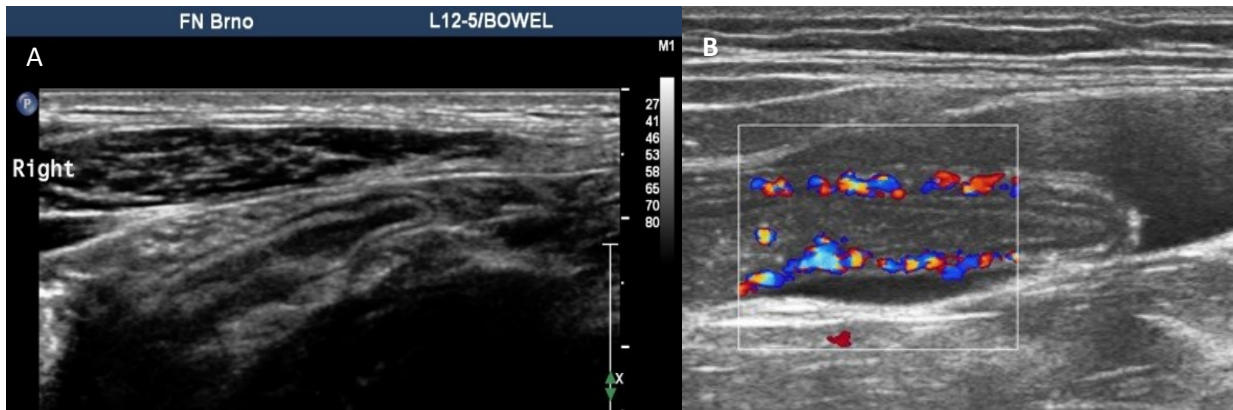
A - Normal appendix (longitudinal plane) on ultrasound.
